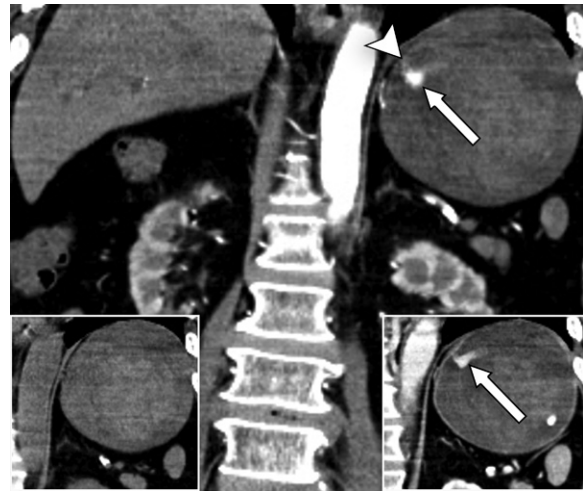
Active bleeding from a Dieulafoy lesion in the proximal stomach in a 62-year-old man with a history of massive hematemesis. Coronal arterial phase (main image), non-contrast (left inset), and portal venous phase (right inset) CTA images show a small hyperenhancing Dieulafoy lesion in the proximal stomach (arrowhead in main image) with a contiguous focus of contrast extravasation in the arterial phase (arrow in main image), which changes in size, attenuation, and shape in the portal venous phase (arrow in right inset). Figure E5 is an image during upper endoscopy that shows a small mucosal defect, containing a visible artery in the proximal stomach, which is consistent with a Dieulafoy lesion. There was no active bleeding at the time of endoscopy.
